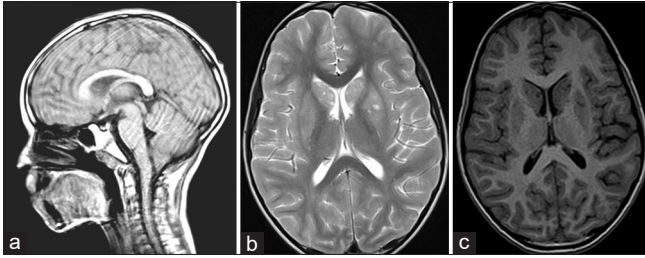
(a-c) From left to right; sagittal T2-weighted magnetic resonance image (MRI) scan showing caudal descent of cerebellar tonsils below the foramen magnum, second image showing axial T2-weighted MRI scan with discrete hyperintense lesions on the head of the caudate lobe and the putamen, third image showing corresponding T2 hypointense areas.
